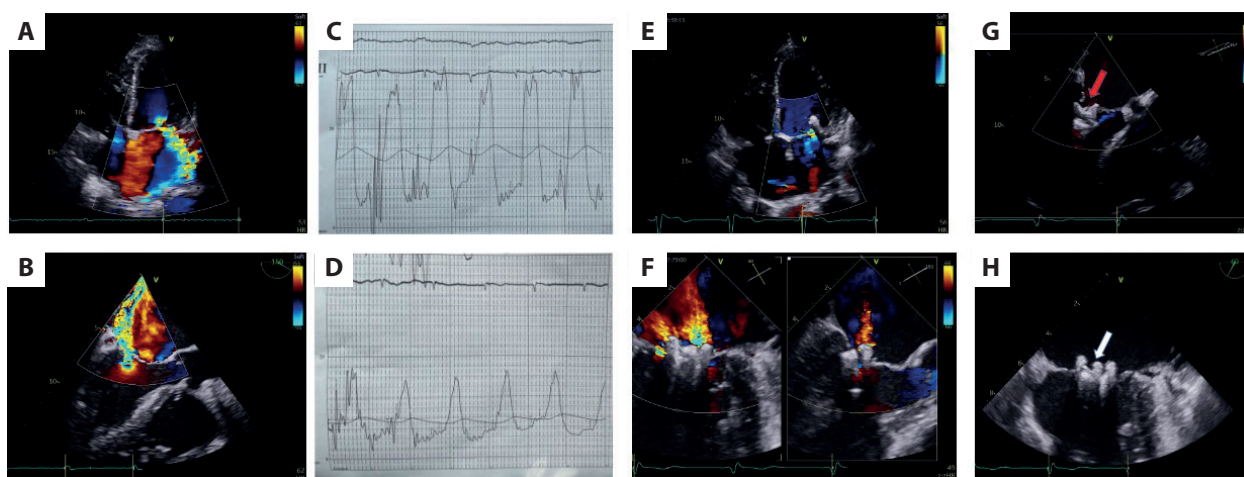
Echocardiographic and hemodynamic evaluation before, during, and after the transcatheter edge-to-edge repair (TEER) procedure. A. Transthoracic echocardiography with significant functional mitral regurgitation (MR). B. Transesophageal echocardiography with significant functional MR. C. Left atrial pressure before the TEER procedure. D. Left atrial pressure after the TEER procedure. E. Transthoracic echocardiography at 30-day follow-up. F. Immediate intraprocedural echocardiographic result after implantation of two Pascal ACE devices medially and laterally to P-10 with single leaflet detachment. G. Single leaflet detachment of the Pascal P-10 device (red arrow points at the gap between P-10 and the posterior leaflet). H. Transesophageal appearance of Pascal P-10 stabilized by two Pascal ACE devices (white arrow points at the P-10 device)
